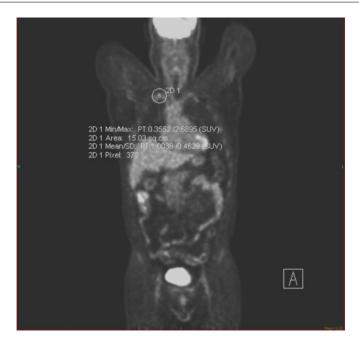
Coronal PET imaging shows avidity in the region corresponding to the right costoclavicular ligament, with an SUV of 2.6.
